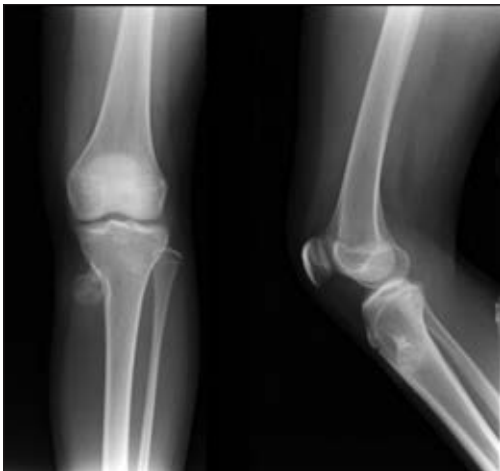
Preoperative X-ray of a 17-year-old boy
